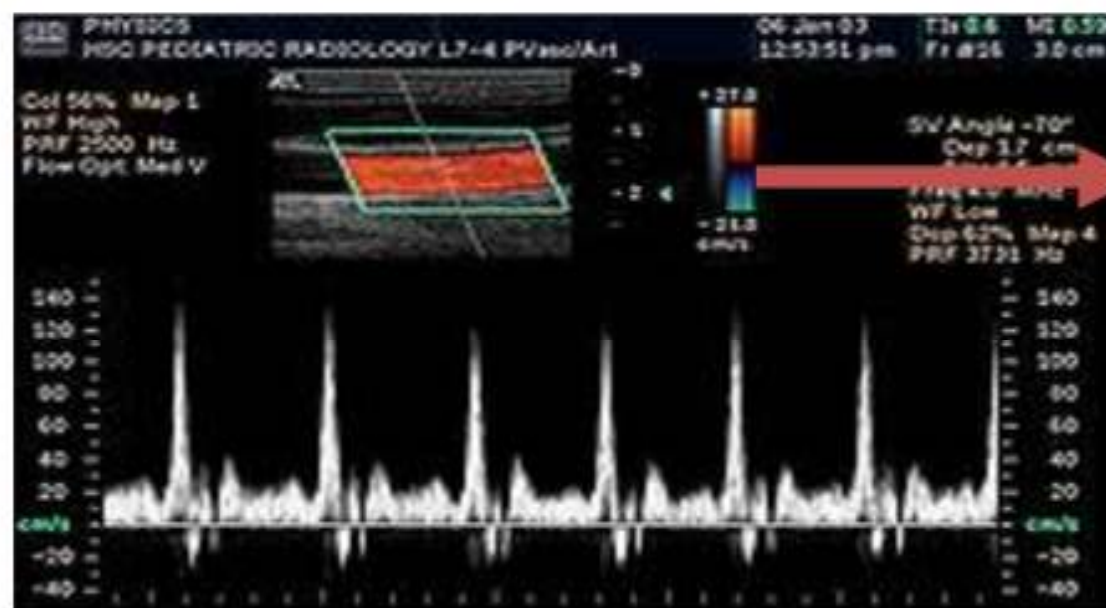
Doppler ultrasound imaging.
